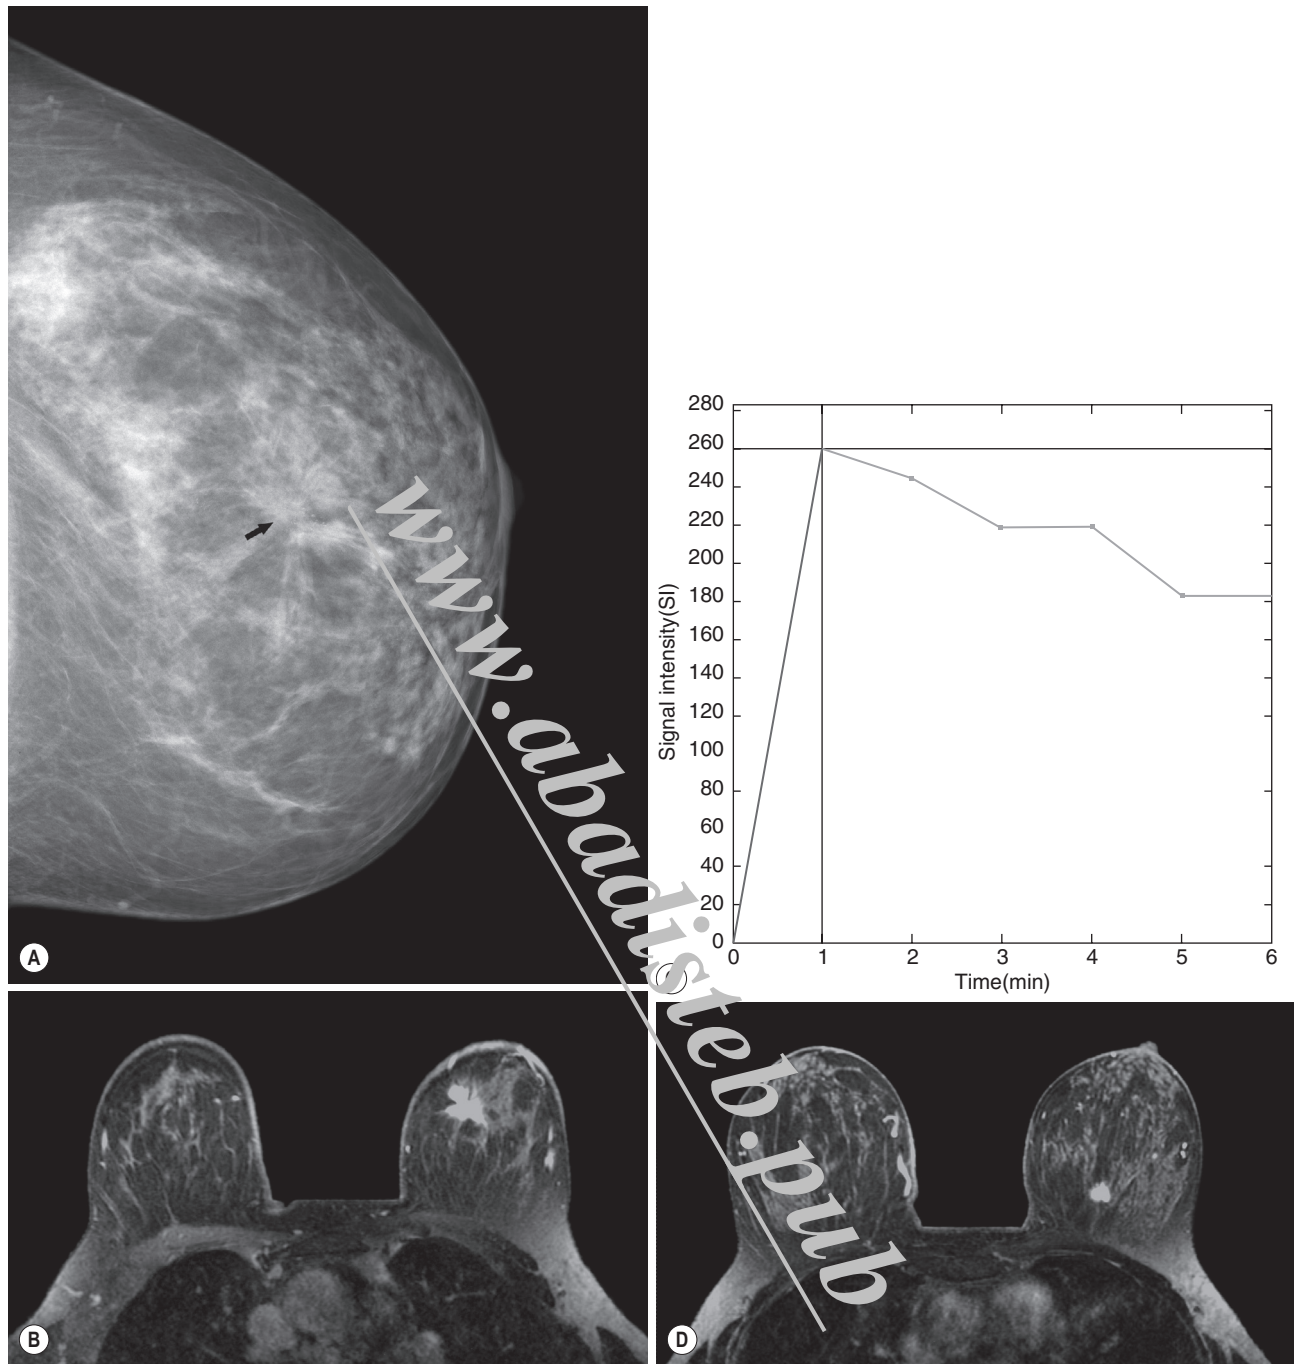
Magnetic Resonance Imaging for Local Tumour Staging. This patient presented with a mass in the left breast. Mammography showed a spiculate lesion (*arrow*) lying centrally within the breast, best appreciated on the craniocaudal view (A). Biopsy indicated a carcinoma with lobular features. Magnetic resonance imaging confirmed the presence of a malignant spiculate lesion (B) with a typically malignant enhancement curve (rapid uptake of contrast agent followed by a washout phase) (C). An additional tumour focus was identified away from the primary tumour site (D). This was confirmed at biopsy.
